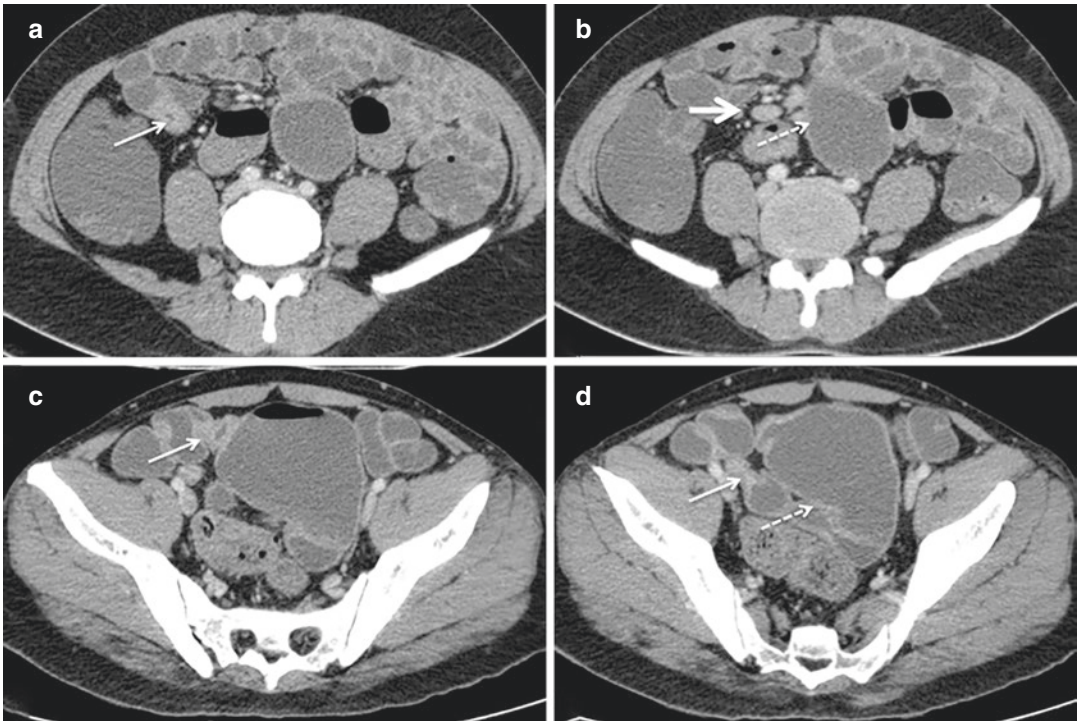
44-year-old man who presented with iron deficiency anemia. (a–d) Axial contrast-enhanced CT enterography images show multiple areas of short-segment circumferential mural thickening and narrowing
